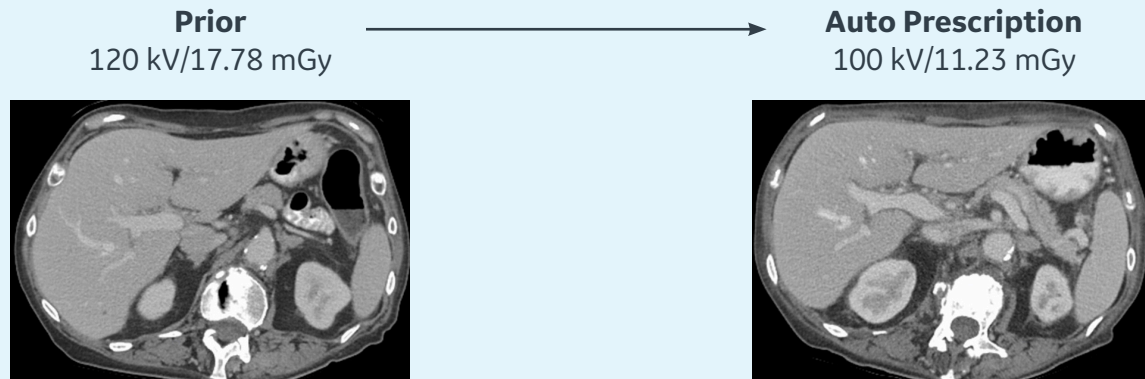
Same patient scanned on Revolution CT at 100 kV/17.78 mGy without Auto Prescription and at 100 kV/11.23 mGy with Auto Prescription (GE Abdomen/Pelvis Reference Profile). Both images were reviewed by a radiologist and rated above acceptable image quality. Reconstructions were performed using DLIR-L.
